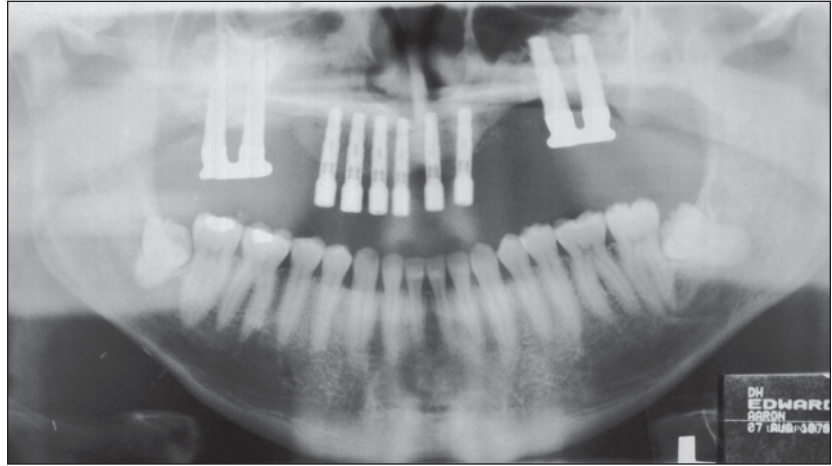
Orthopantomogram showing anterior 6 Frialit-2 implants in situ.
